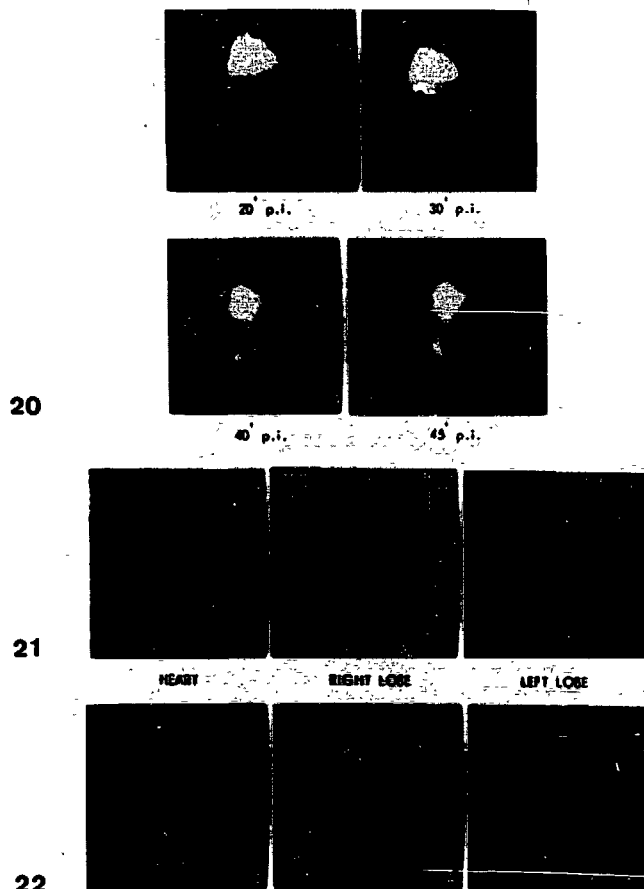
20-22 Cholescintigraphy in a patient with multiple stones
